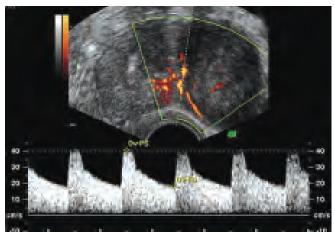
Moderate vascular impedance blood flow signals are isolated from the fibroid vessels using pulsed Doppler waveform analysis
